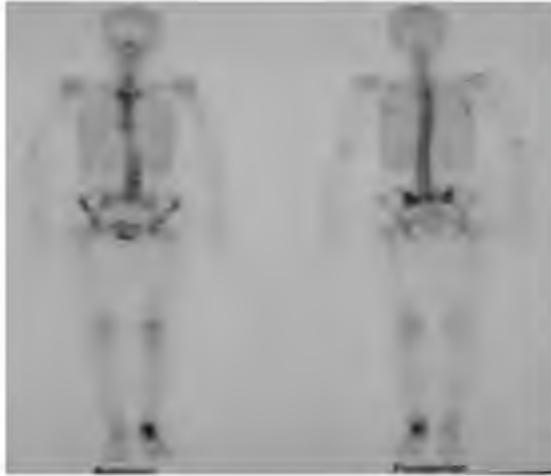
Preoperative scintigraphic views of the patient
